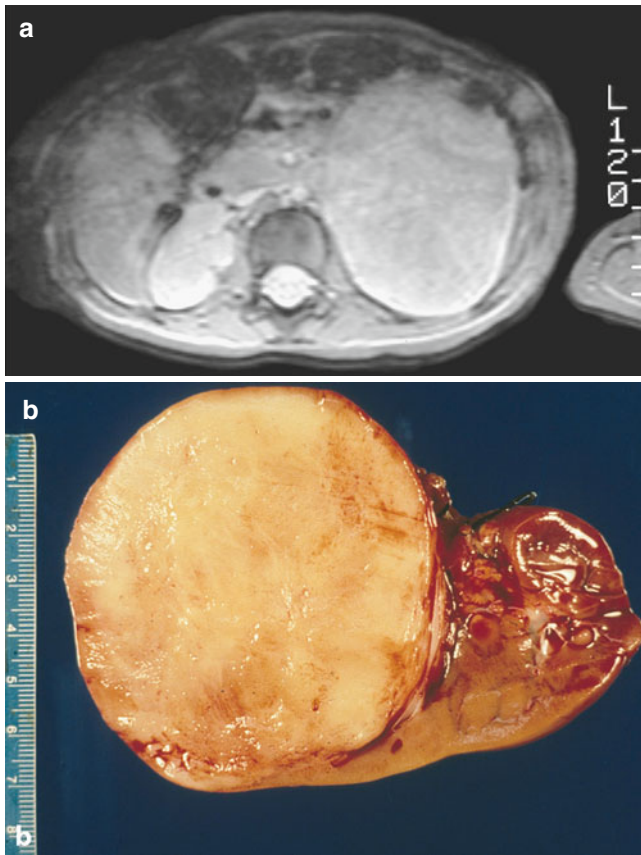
(a) MRI scan of a 21 month old female who presented with a palpable left flank mass. (b) Cut surface of the tumor reveals homogeneous texture of the tumor consistent with clear cell sarcoma of the kidney
